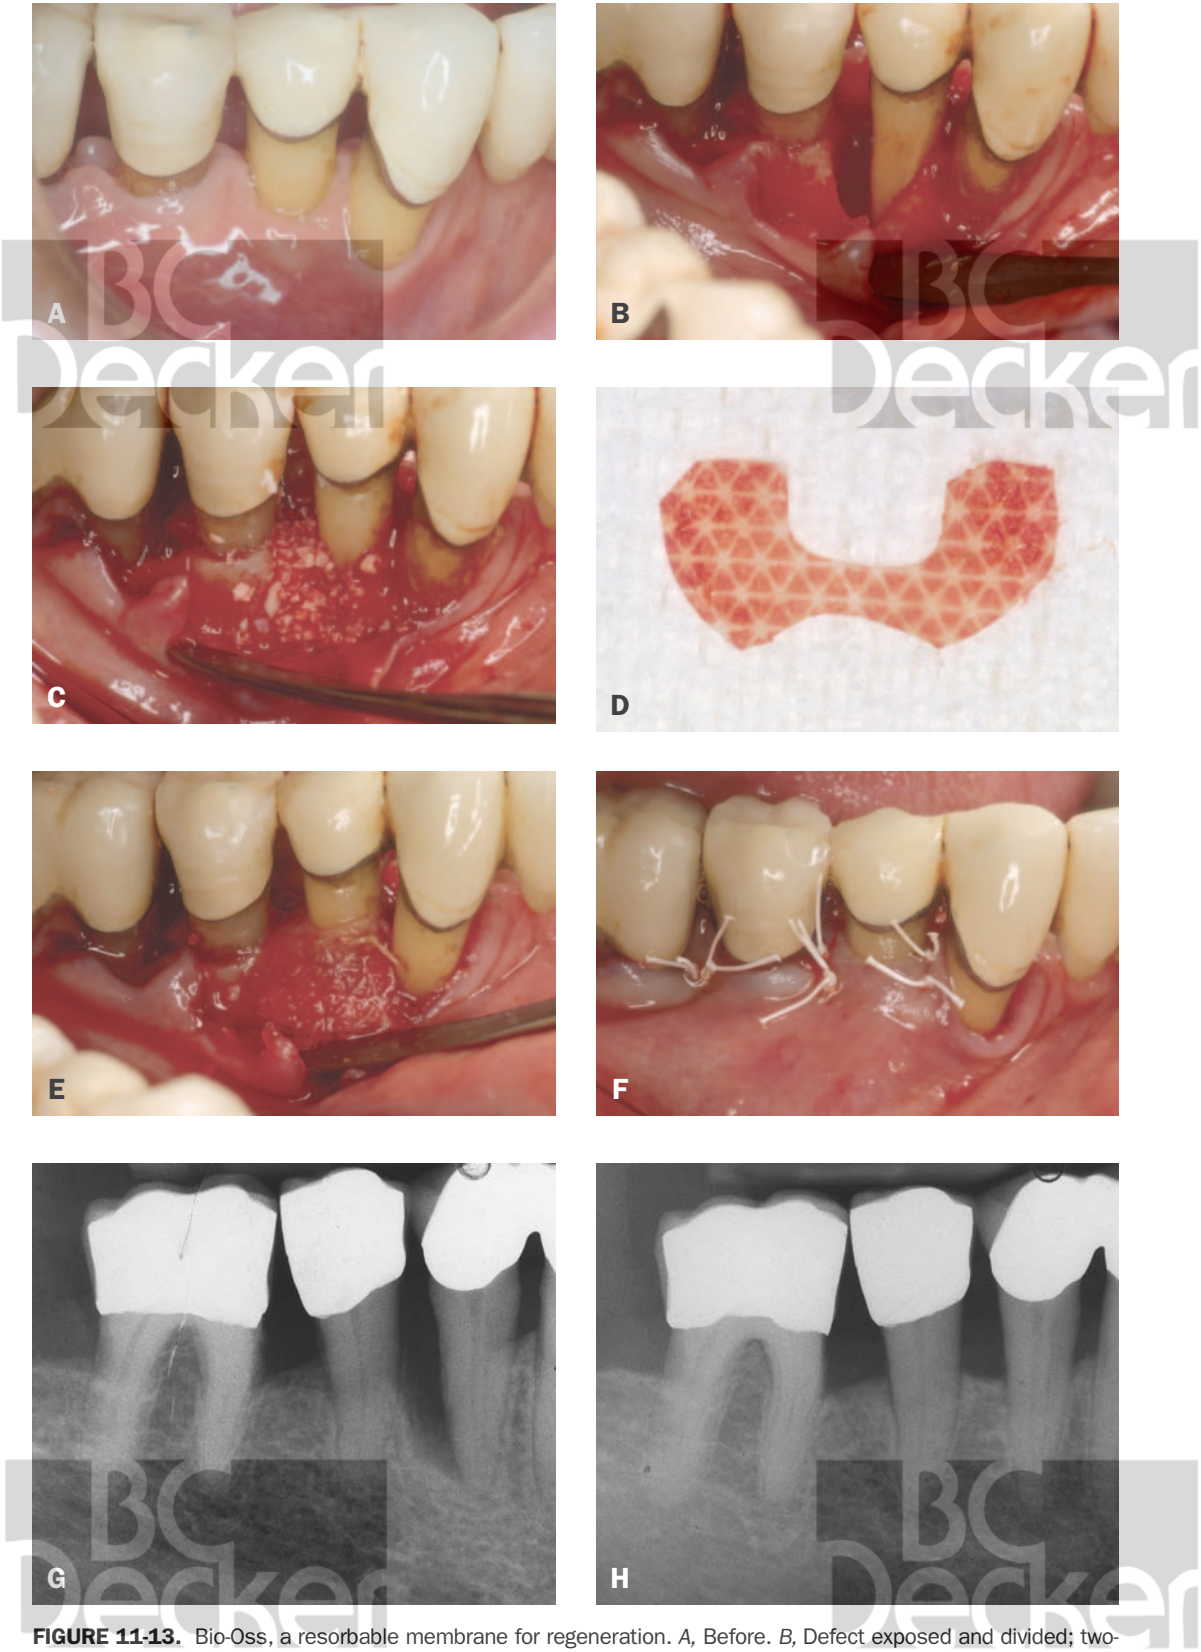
Bio-Oss, a resorbable membrane for regeneration. *A*, Before. *B*, Defect exposed and divided; two- to three-wall defect. *C*, Bio-Oss placed in defect. *D*, Resolute membrane contoured. *E*, Membrane sutured to position. *F*, Primary closure with Gore-Tex sutures. *G*, Starting x-ray. *H*, 1 year later with complete radiographic bone fill.
